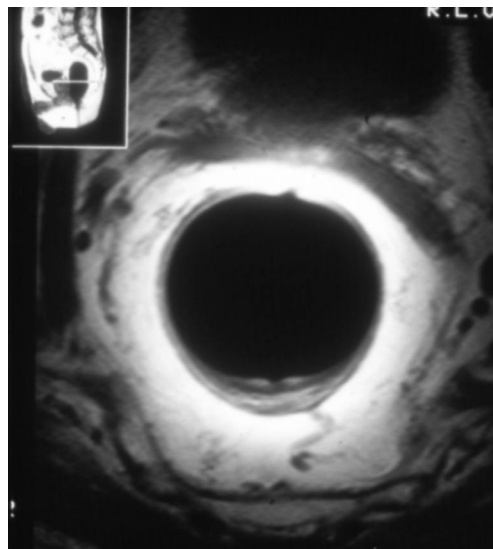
Intra-anal magnetic resonance imaging showing T1 rectal tumour that is suitable for local contact radiotherapy or transanal endoscopic microsurgery.
